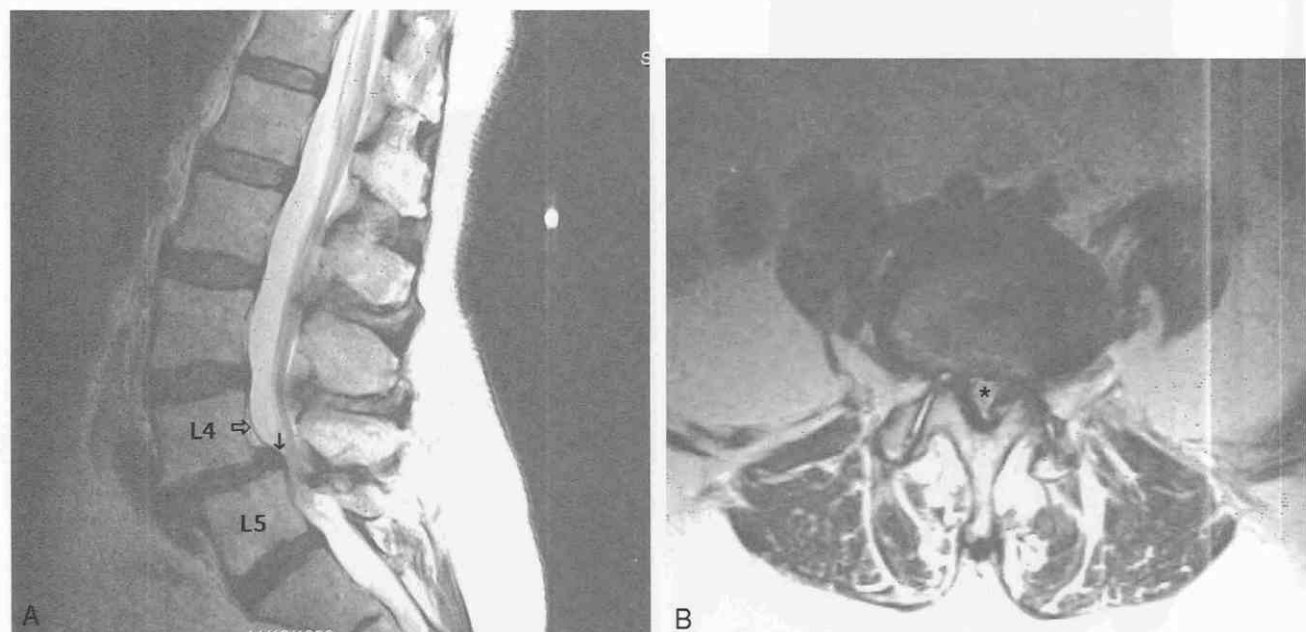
A*, Spondylolisthesis. Sagittal T2-weighted image of spondylolisthesis of the L4 vertebra off L5. Note the severe canal stenosis caused by the slippage. The disk (closed arrow) is exposed by the slippage of L4, giving the false impression of herniation (“pseudoherniation”). The posterior longitudinal ligament (open arrow) is displaced by the spondylolisthesis. *B*, Axial scan at the L4-5 level of the same patient as in *A*. Note severe stenosis of the canal (asterisk).
